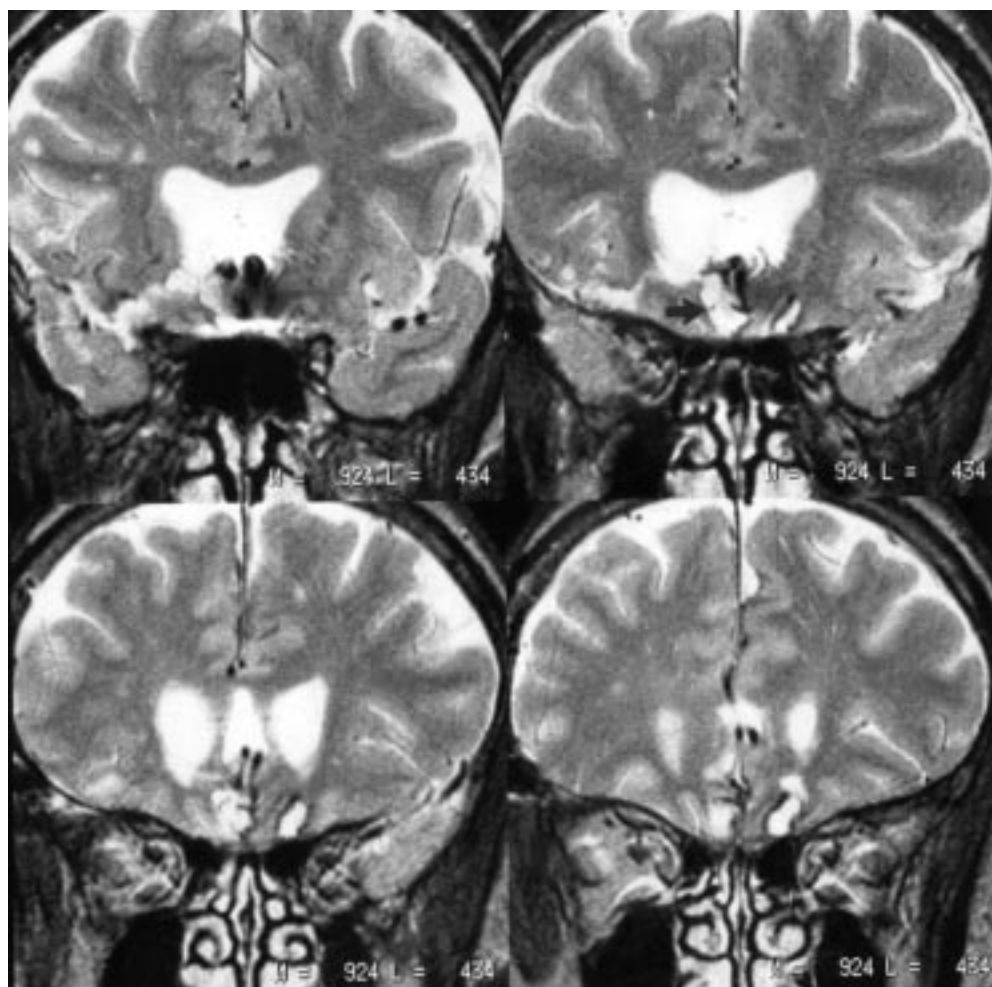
T2 weighted MRI of patient 4; coronal sections show (especially in the top right—black arrow—and bottom left) involvement of the right sided MS/ndbB complex as well as bilateral lesions of the rectus gyri together with the clip artefact.
